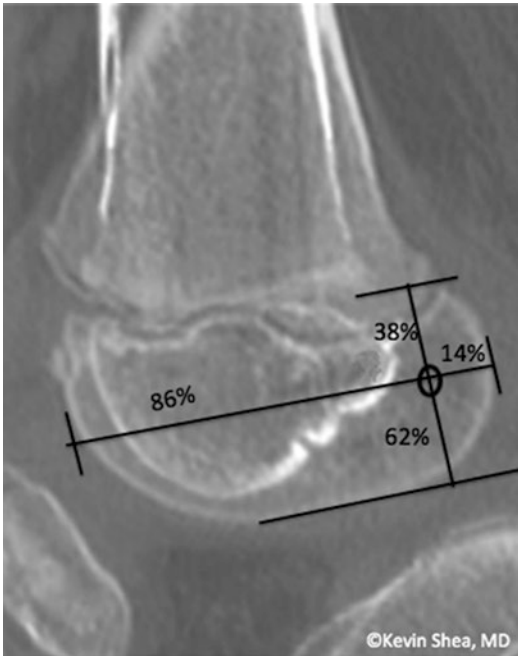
Merged CT images showing the 95% confidence intervals for ACL origin. Published with kind permission of © Kevin Shea 2017. All Rights Reserved
